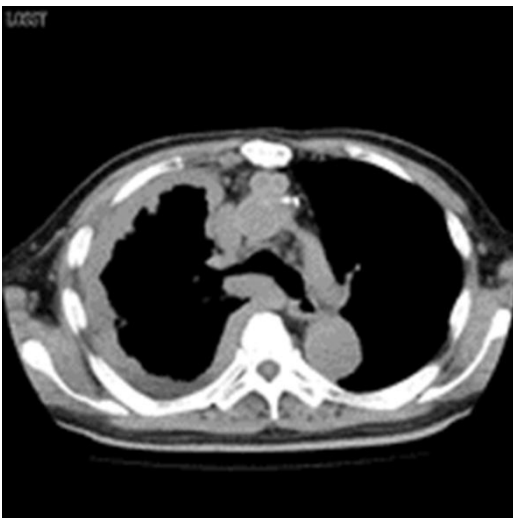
In the chest CT mediastinal window of this pleural mesothelioma case, the right pleura diffusely presents with irregular hyperplasia and covers the unilateral pleura (pleural rind). Then the right thorax narrows.
